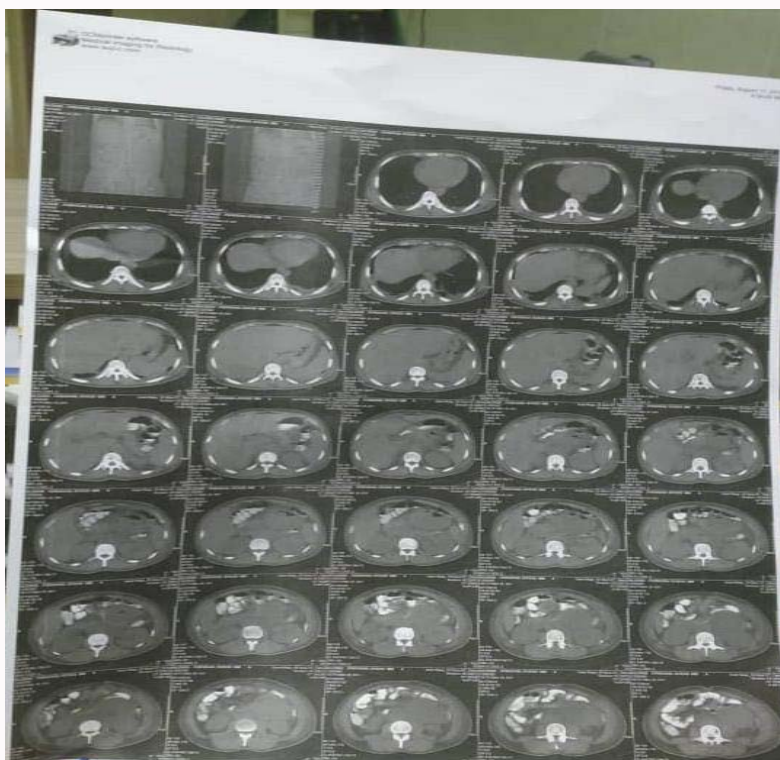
CT of abdomen which discloses collection on left side.
